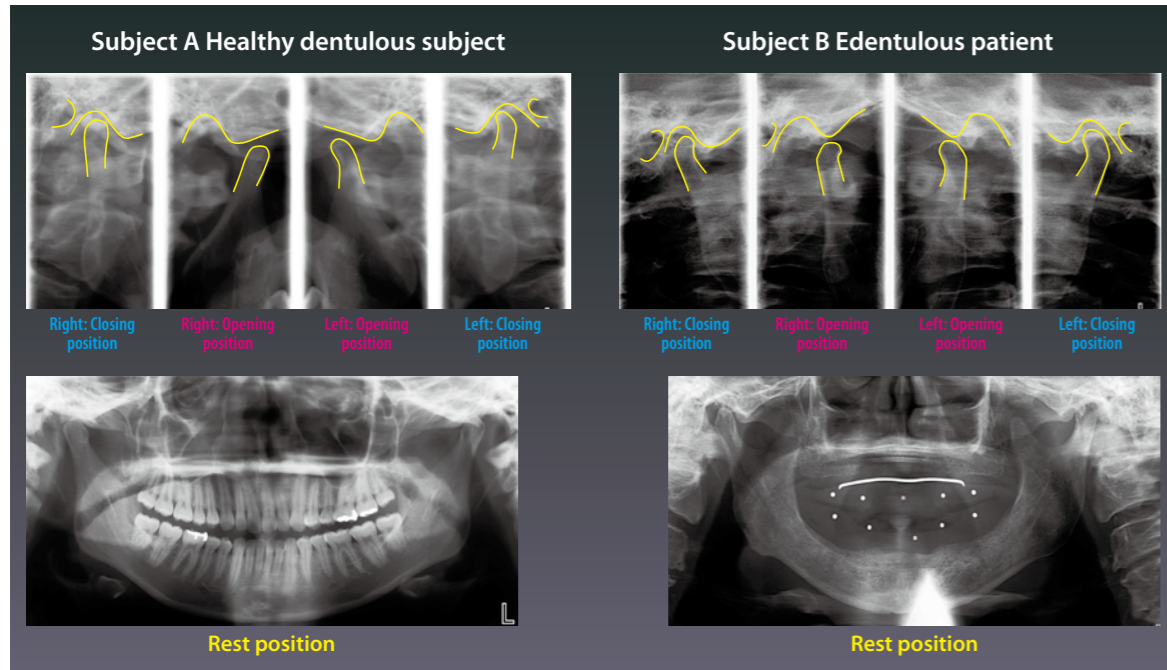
Radiographic views. No abnormalities were confirmed in the temporomandibular joints.
